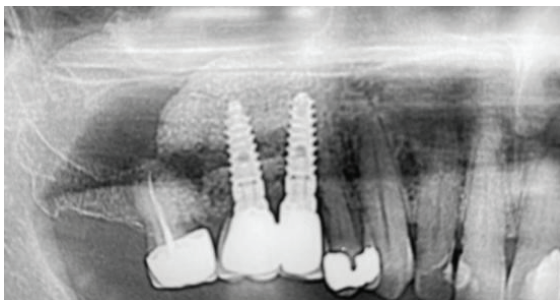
panoramic radiograph taken 3 years after loading
